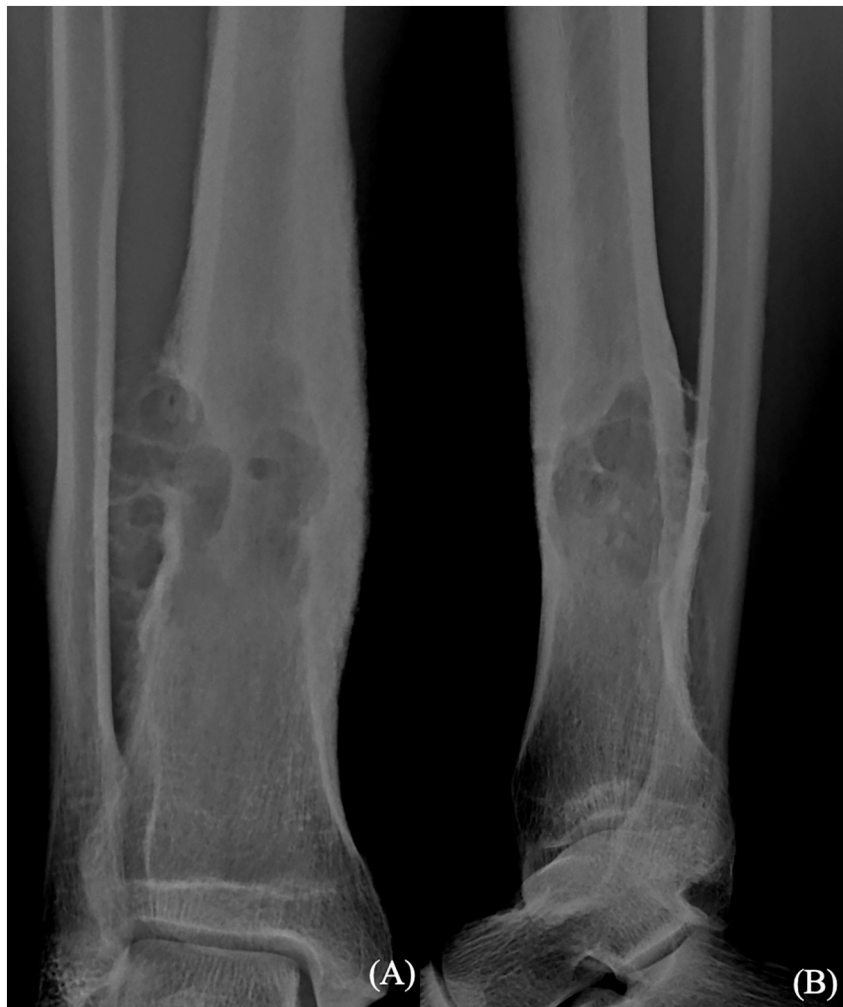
AP (A) & Lateral (B) radiograph of right distal tibia with lytic lesion at the lateral cortex.
